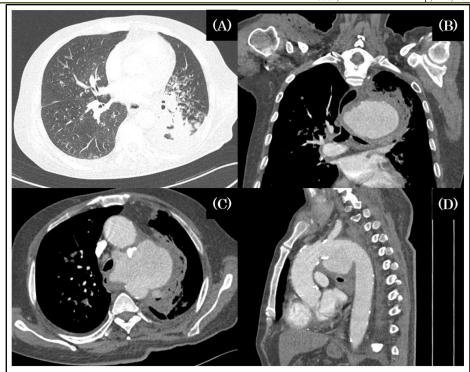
Follow-up chest CT showing persistent infection and vascular progression (30 March 2025).
